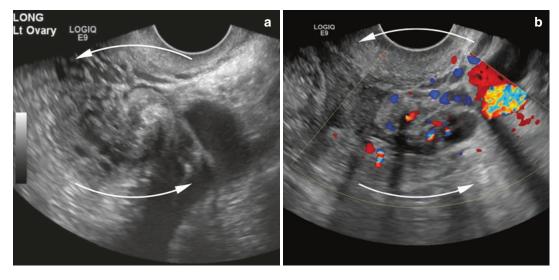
Transvaginal US in a 38-year-old female with acute onset pelvic pain. A single grayscale screen capture from a cine video clip (\mathbf{a}) in the left adnexa demonstrates a swirling appearance of the vessels leading to the ovary ("whirlpool sign"). Doppler imaging (\mathbf{b}) confirms the swirling pattern is vascular with small amounts of flow
